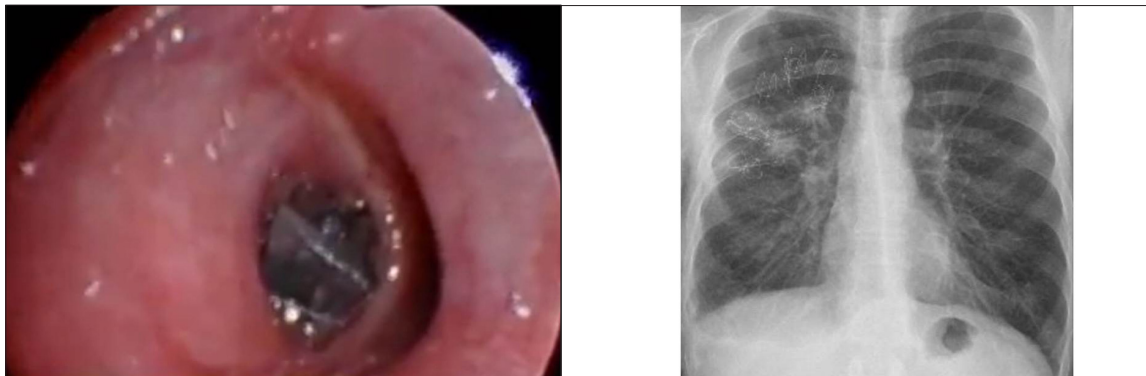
View of the endobronchial valve in the posterior segment of the right upper lobe (left). Endobronchial coils on chest radiograph (right).
